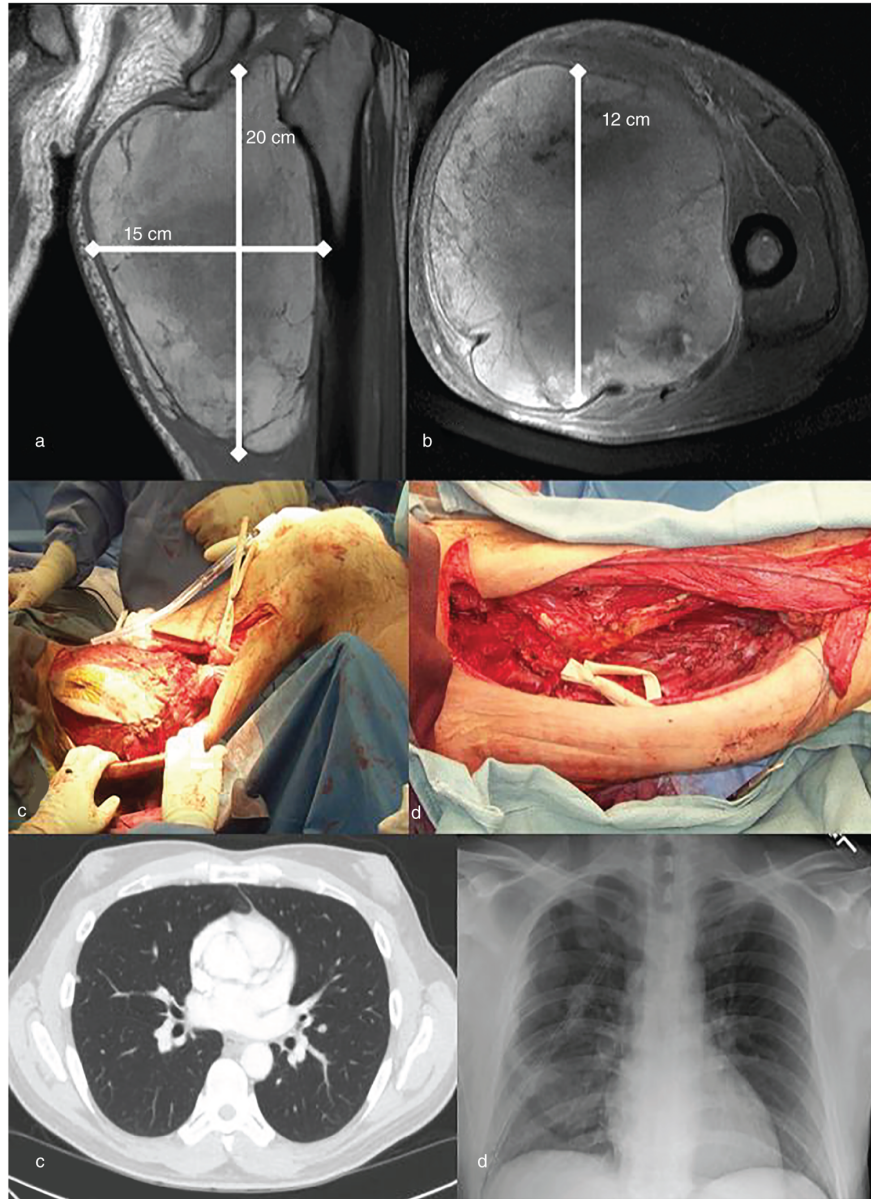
Clinical images of patient presented embody the inherent difficulty in treatment of high-risk STS. Pretreatment MRI scans revealed a large 20 × 15 × 12 cm mass in the left medial thigh (A, B). Following neoadjuvant radiation therapy, the patient is taken to the operating room for a wide excision of the tumor (C). Post resection, the sciatic nerve is skeletonized, tagged with a vessi-loop (D). Despite negative margins, no prior evidence of lung involvement on staging studies, and no evidence of local recurrence, the patient developed radiographically detectable lung metastases on CT scan nine months following definitive resection (E). Following treatment with adjuvant chemotherapy (adriamycin and ifosfamide/mesna), the patient underwent pulmonary metastatectomies (F). Source: Robert J. Wilson, Jennifer L. Halpern, Jill Gilbert, Ginger E. Holt, Vicki L. Keedy, Herbert S. Schwartz.
